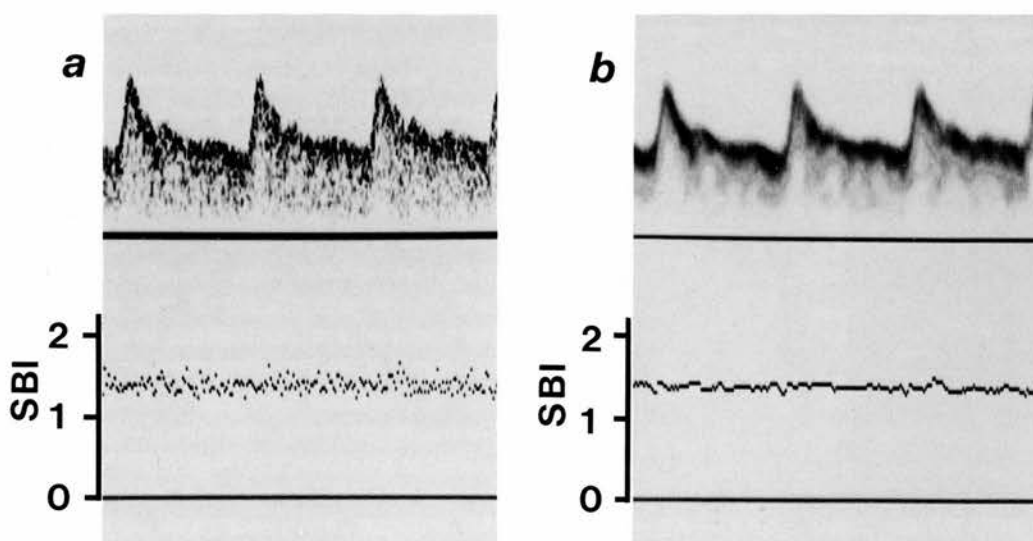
Internal carotid artery Doppler spectra, (a) before filtering and (b) after filtering with optimal directional filter. The spectral broadening index SBI is F_{\max}/F_{mean} . This index shows less variability with time when calculated from the filtered Doppler waveforms.
